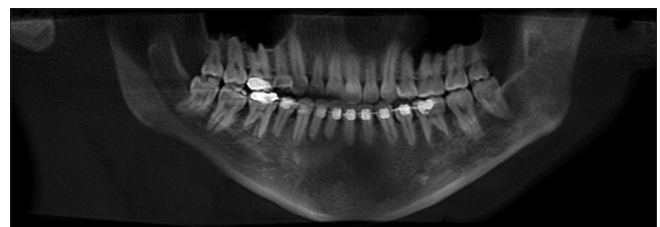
Computed tomography panoramic view evidencing remission of the lesion after 4 years of therapy
